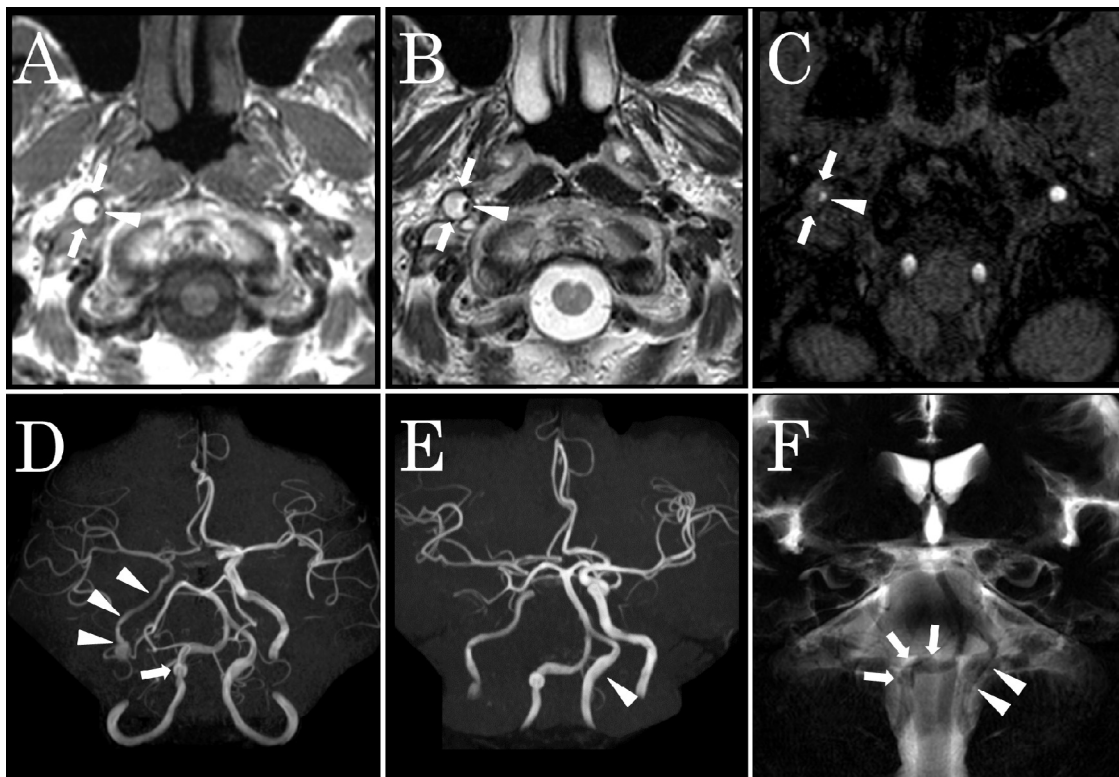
Magnetic resonance image on admission. Right ICA dissection on axial T1-weighted imaging (A) and T2-weighted imaging (B) showing a typical eccentric hyperintense signal of the ICA in correspondence with the mural hematoma (arrow) surrounding the residual lumen (arrowhead). The external diameter of the right ICA is markedly enlarged in comparison with the left ICA. Additionally, MRA source imaging reveals hypointense signal of the mural hematoma in the right ICA (C, arrowhead). MRA shows a narrowing and reduced signal intensity in the right ICA and middle cerebral artery (D, arrowhead), a dissecting aneurysm of the right VA (D, arrow), and dilatation of the left VA (E, arrowhead) at the skull base. Basiparallel anatomical scanning shows bilateral VA dilatation (F; right VA, arrows; left VA, arrowheads). Abbreviations: ICA, internal carotid artery; MRA, magnetic resonance angiography; VA, vertebral artery.
